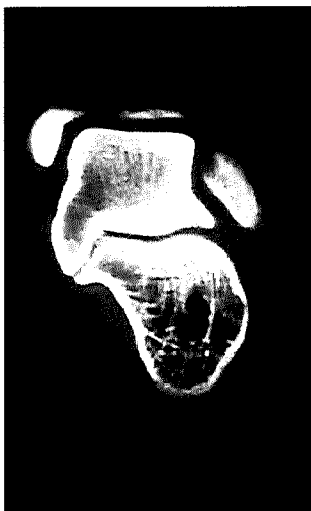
Talocalcaneal coalitions are best seen on computed tomography (CT) scans taken in the coronal plane. The middle facet is very narrow, irregular, and down-sloping. The posterior facet is more narrow than the ankle joint. And the calcaneus is in valgus alignment. (From Mosca VS. Flexible flatfoot and tarsal coalition. In: Richards B, ed. *Orthopaedic knowledge update: pediatrics*, Rosemont, IL: American Academy of Orthopaedic Surgeons, 1996:211, with permission.)
